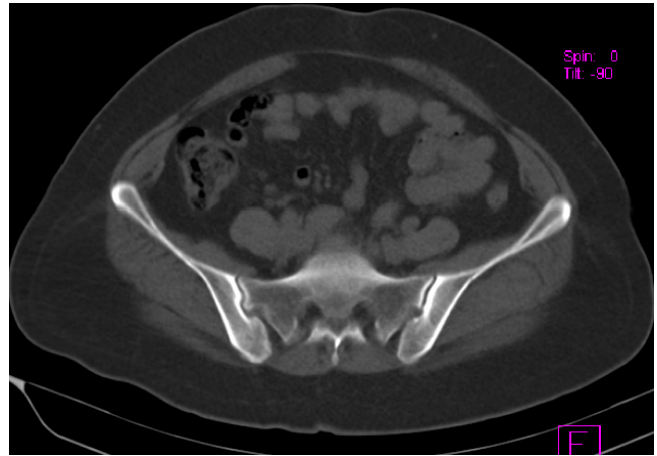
No change/minor non-specific change in right iliac bone (↑ CT density)
